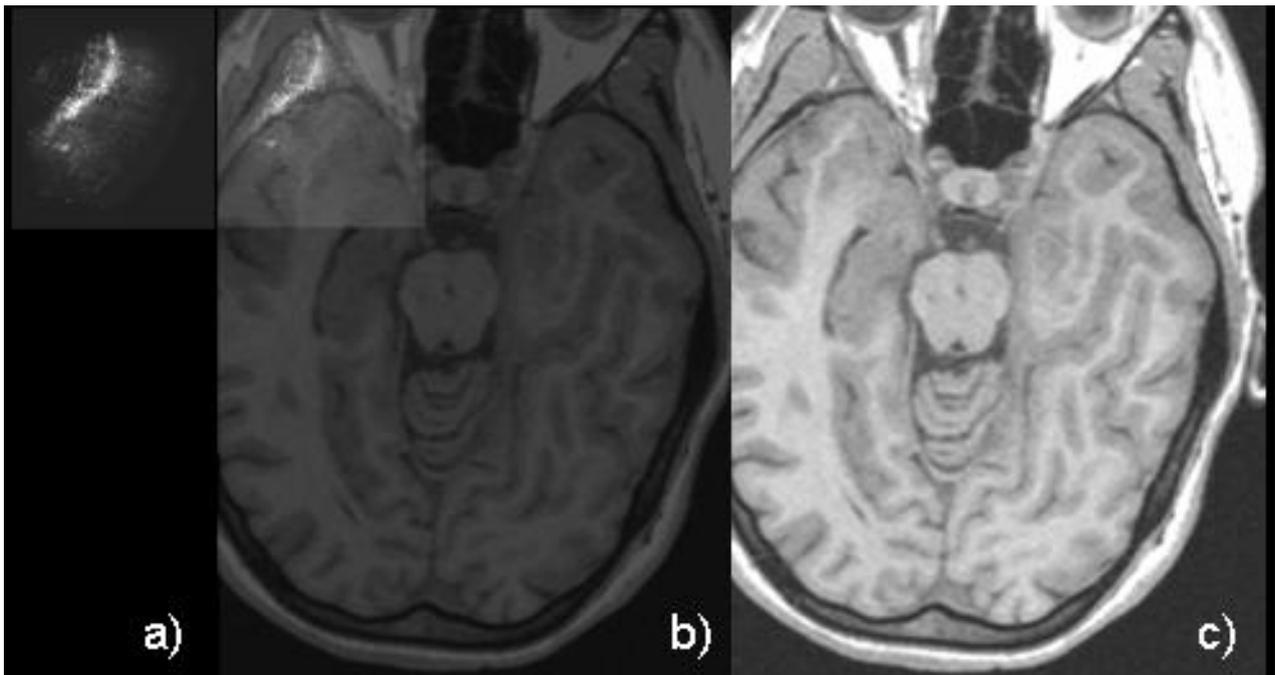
(a) Axial ultrasound image of the temporal region; (b) superimposed axial ultrasound and registered MR image; (c) corresponding axial MR slices
